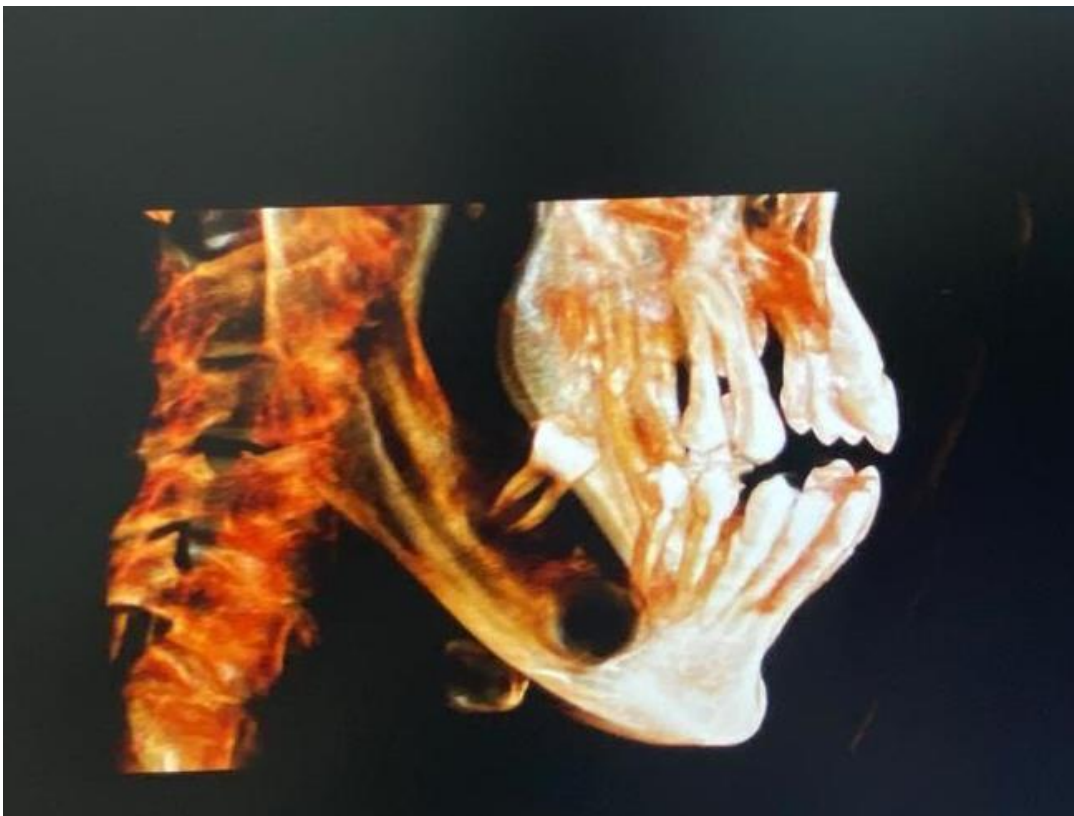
Three-dimensional view of full craniofacial appearance using CBCT showing small periapical pathology of the related mandibular second left molar.
